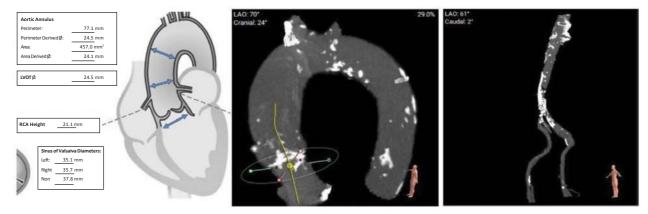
Pre-planning CT, with 3-Mensio analysis. Adequate coronary heights and sinuses were noted despite calcifications in the aortic arch and iliac bifurcation.
